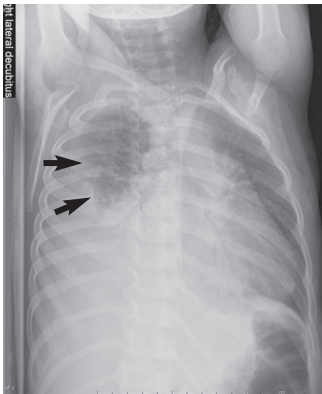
Right-side-down decubitus radiograph of the child in Figure 32-1. The fluid is more prominent on the lateral chest wall margin, indicating free movement of the fluid in the pleural space (*arrows*).
